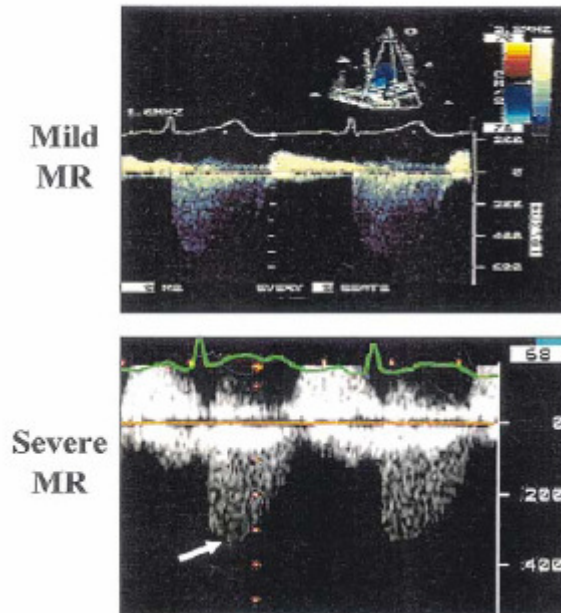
Continuous wave Doppler recordings. In mild MR, the MR jet has a soft density with a rounded contour. In severe MR, the jet is dense with a triangular jet (*arrow*) (Zoghbi *et al.*, 2003).
